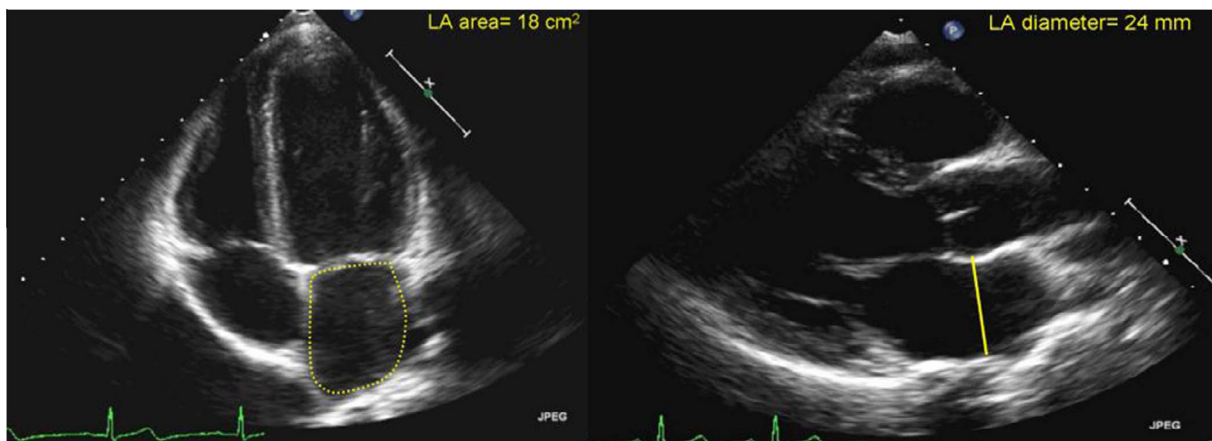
Measurements of left atrial area (before mitral valve opening) in the apical 4 chamber view (on the left side) and left atrial anterior–posterior diameter in the parasternal long axis view (on the right side).
